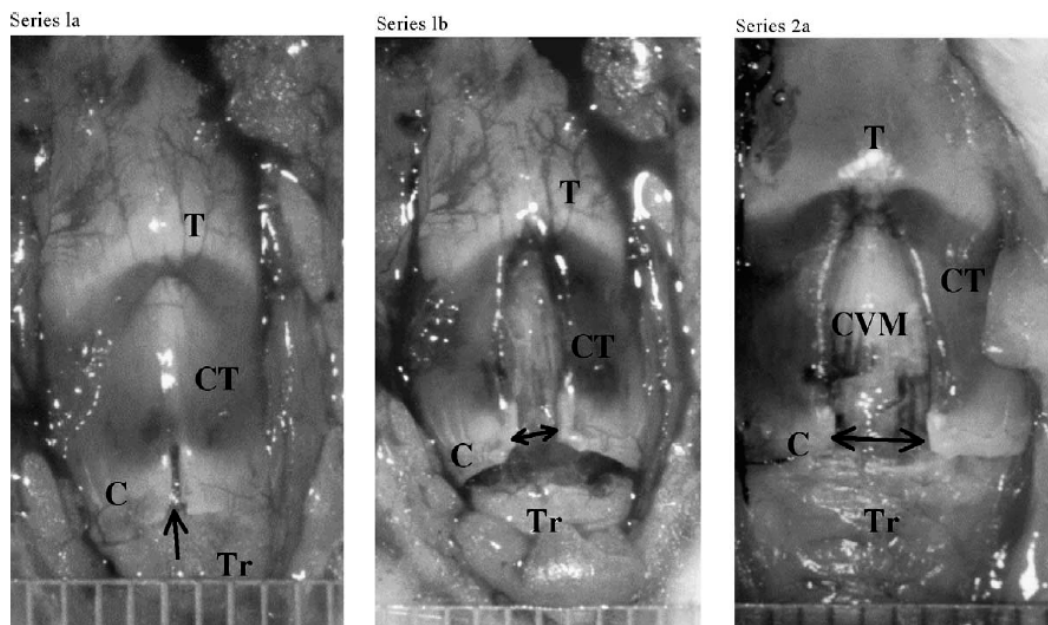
Ventral view of the larynx at 8 weeks; see Table 1 for surgery steps. C = cricoid cartilage; T = thyroid cartilage; Tr = first tracheal ring; CT = cricothyroid muscle; CVM = cricovocal membrane; \leftrightarrow gap between the cut ends.
